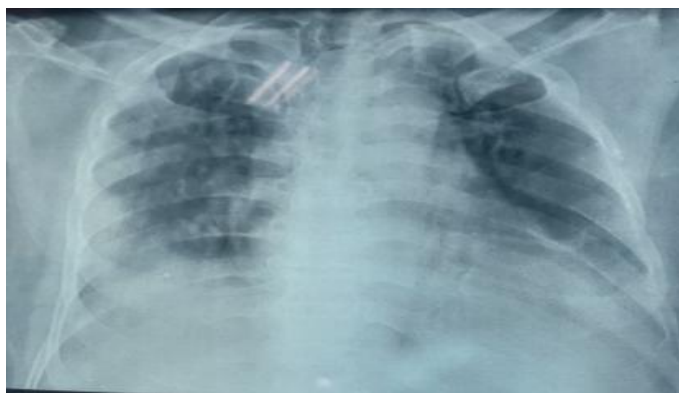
Chest X-Ray showing Air space opacities
